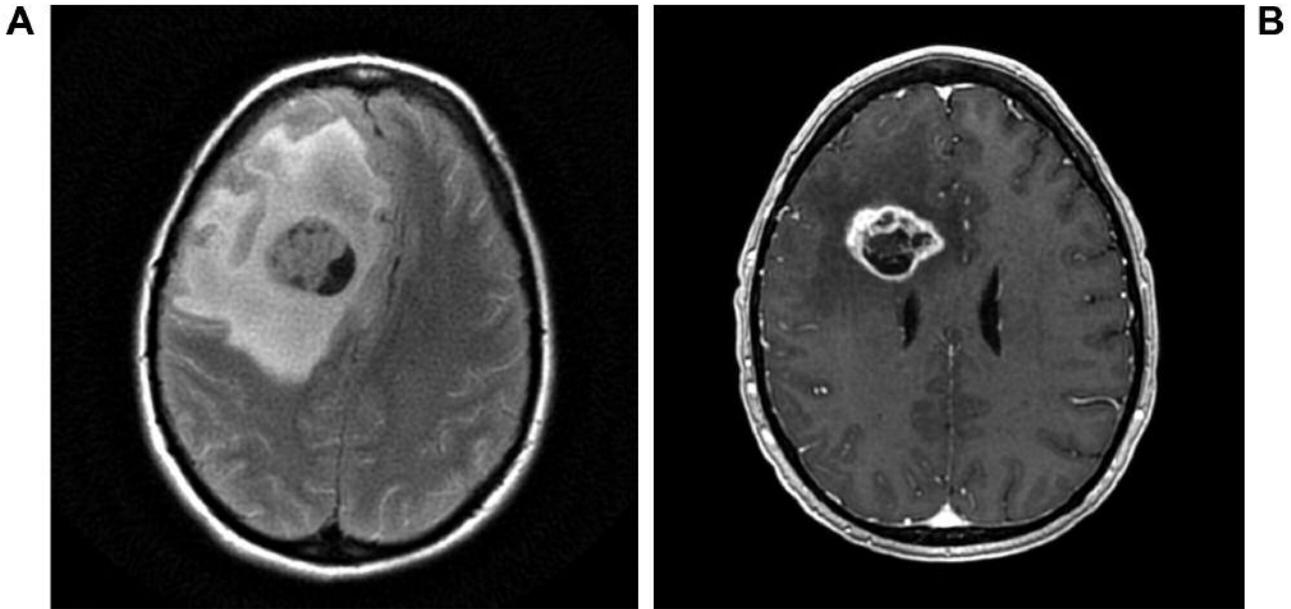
MRI scans of patient 4 at initial presentation and radiographic progression. A: T2 image at initial encounter when patient presented in status epilepticus, initial images were taken without contrast. Pathology revealed to be GBM. B: T1-post contrast MRI obtained 4 months after initial presentation. Baseline MRI at 4 weeks after completion of 6-week course of concurrent radiation with TMZ; pathology confirmed radiation necrosis.
